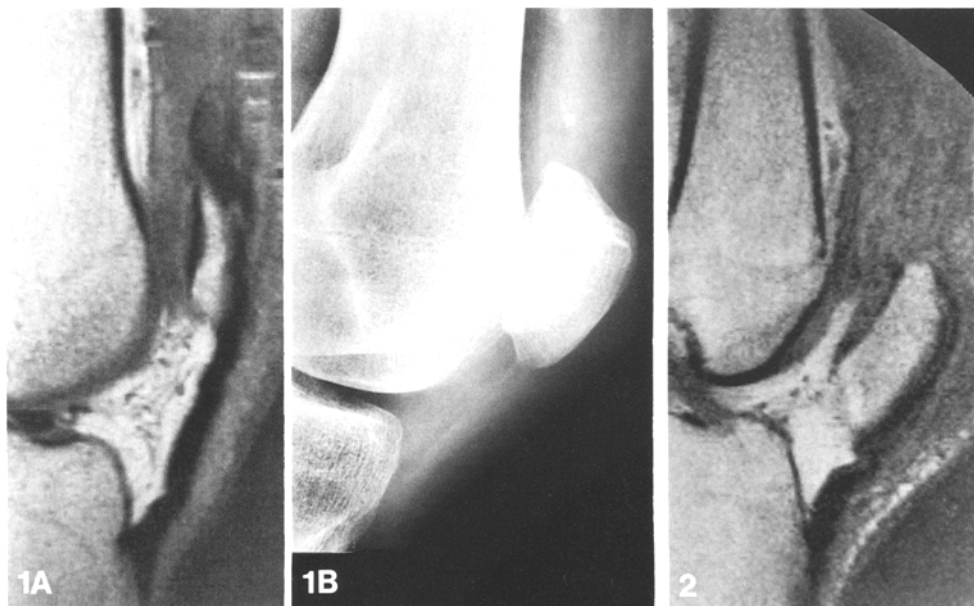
A T₁-weighted magnetic resonance (MR) image in the sagittal plane demonstrates a “wrinkled appearance” to the patellar tendon indicating quadriceps tendon rupture. B Lateral knee radiograph of same patient shows loss of the normal quadriceps tendon outline, suprapatellar calcification, and a “wrinkled” appearance to the patellar tendon
